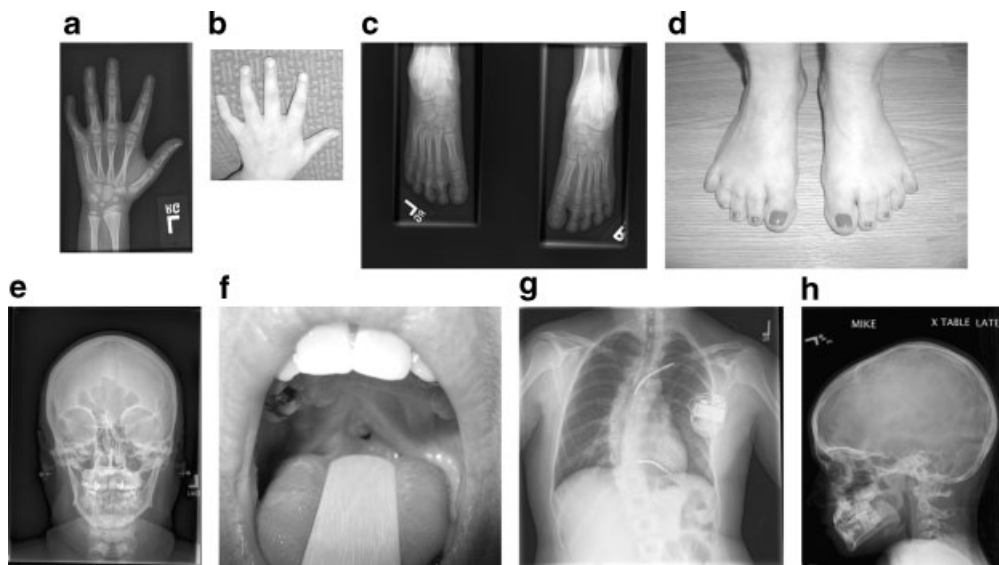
Skeletal and radiographic findings in ATS. Top row (left to right): (a) and (b) Patient 2, age 8 years, 7/12–5th finger clinodactyly, short 1st, 4th, and 5th metacarpals, short 5th proximal and middle phalanges. According to the California standard of Greulich and Pyle, the estimated bone age is 5 years and 9 months. (c) and (d): Clinodactyly of toes 3, 4, 5, brachydactyly, mild cutaneous 2–3 syndactyly, shortening of metatarsals 1, 4, 5. Bottom row (left to right): (e) Prominent frontal sinuses. (f) Residual cleft palate. (g) Gracile ribs and scoliosis with ICD in place. (h) Copper-beaten skull.
